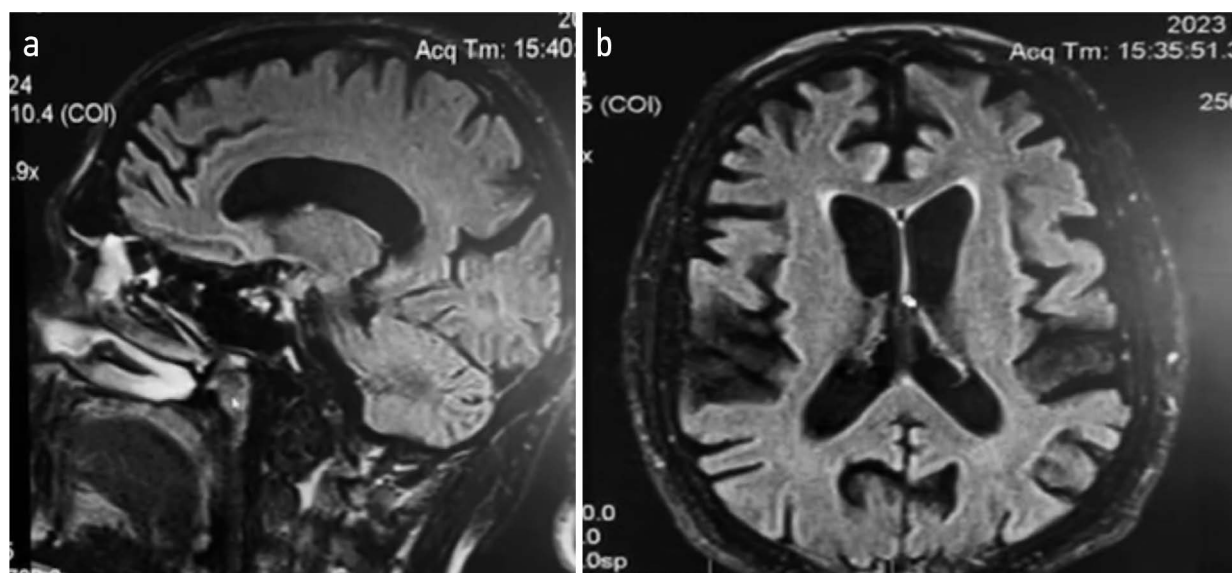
Magnetic resonance imaging of the brain in the sagittal plane (a) and axial plane (b): signs of marked atrophy (predominantly frontal and temporal).
